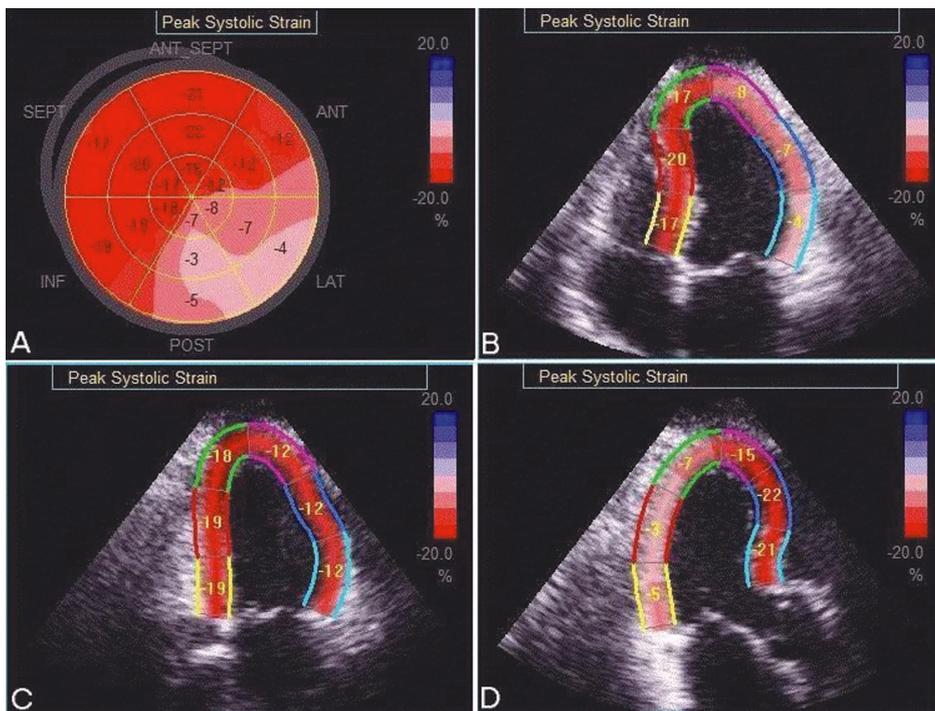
Peak systolic strain of a patient with posterolateral myocardial infarction (MI). [A] Bull's-eye map based on 18 cardiac segments. The color scale is represented in the right upper corner. Low intensity pink color in the posterolateral segments with lower numbers of the peak systolic strain are indicative of posterolateral wall motion abnormalities. [B] Four-chamber view, [C] Two-chamber view, [D] apical three-chamber (long axis) view.
